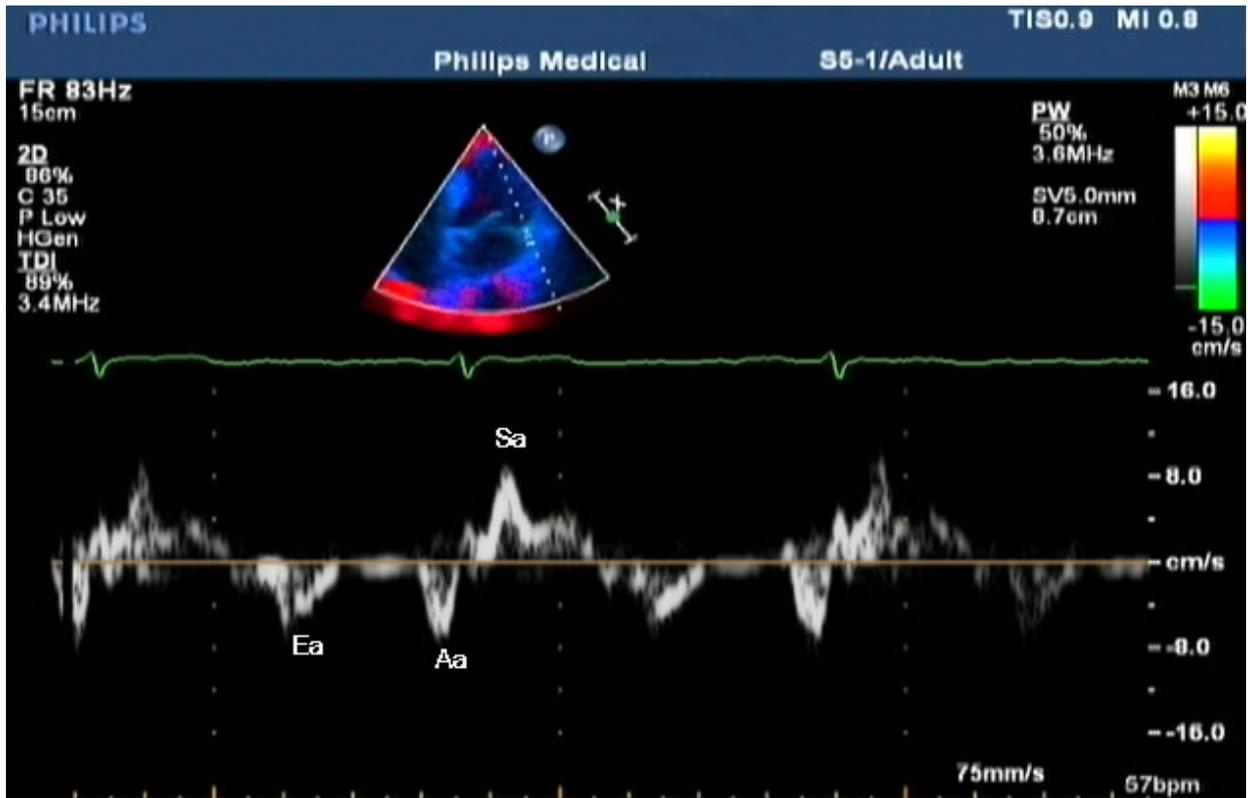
The averages of velocities measured from the lateral mitral annulus on the transthoracic four-chamber views were reported as Sa (Peak longitudinal systolic velocities), Ea (early diastolic velocities), Aa (late diastolic velocities).
